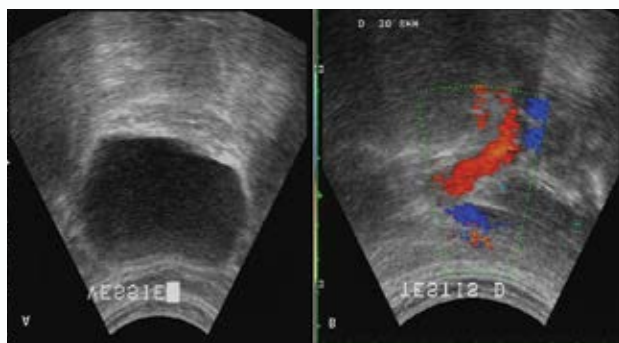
Pelvic ultra sonography: A) Absence of internal genital organs. B) Presence of male gonads in the internal zone of iliac vessels.
